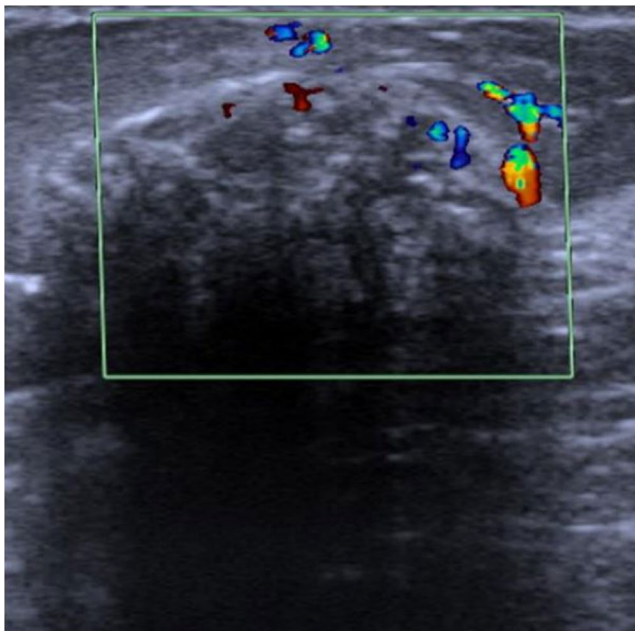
Mammary sonography showing a 28-mm lesion with multiple calcifications and remarkable hyperemia in the left breast
